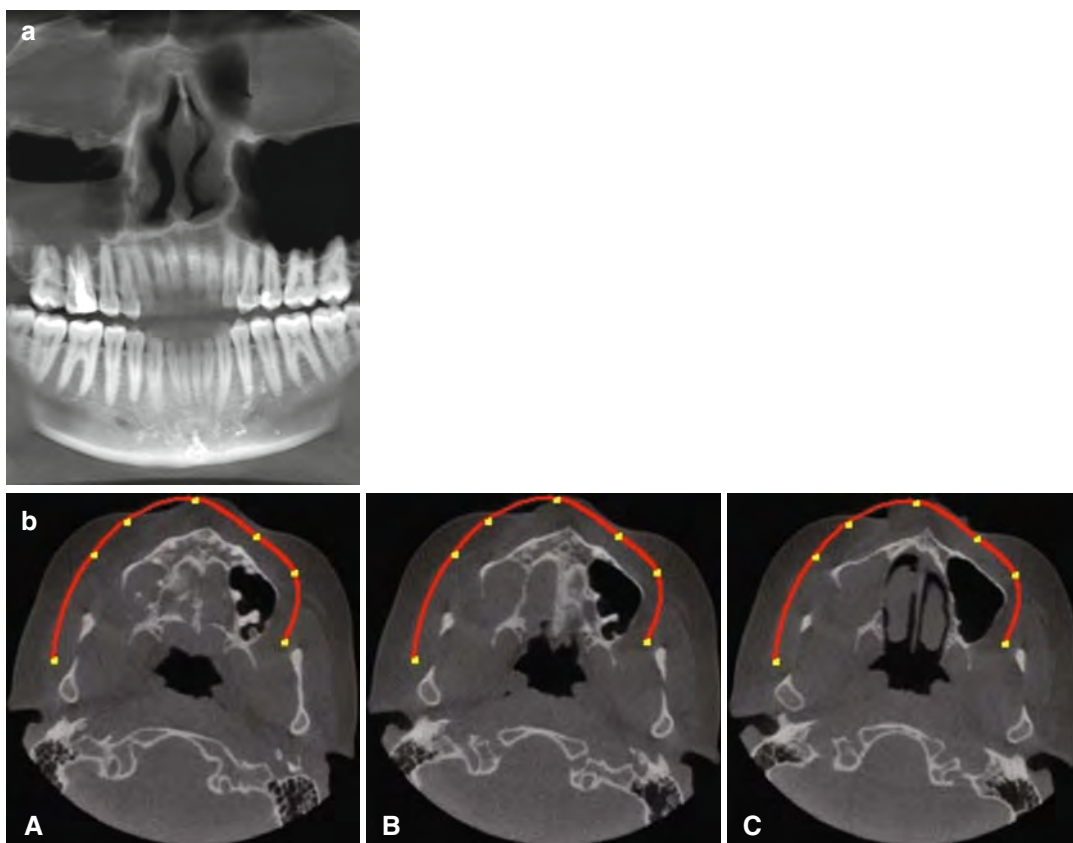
(a) Panoramic CBCT scan demonstrates half of the maxillary sinus associated with endodontically treated tooth which is filled with inflammatory tissue (Courtesy of Dr. Philippe Sleiman, Beirut, Lebanon). (b) Sectional
